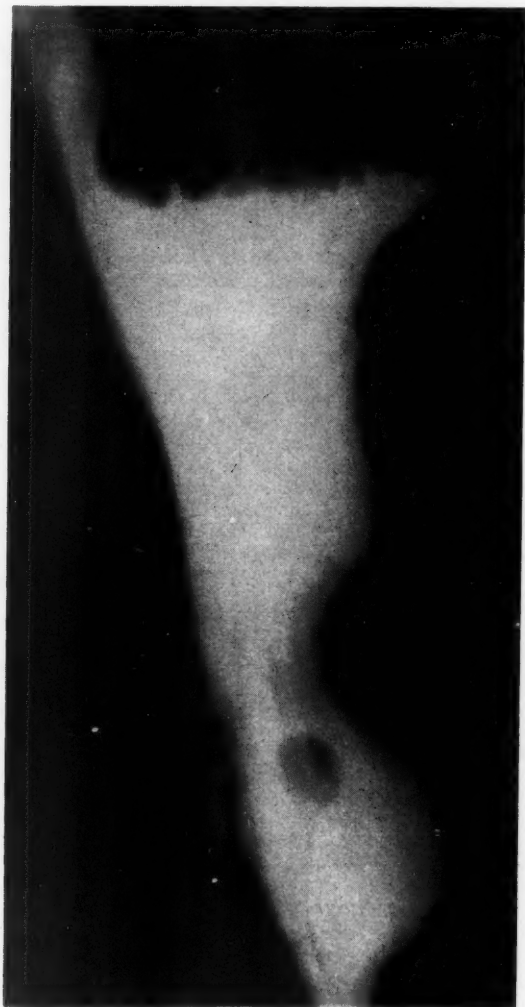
Roentgenographic appearance of the tumor in the stomach. The carcinoid is seen as a polyp in the fundus.
